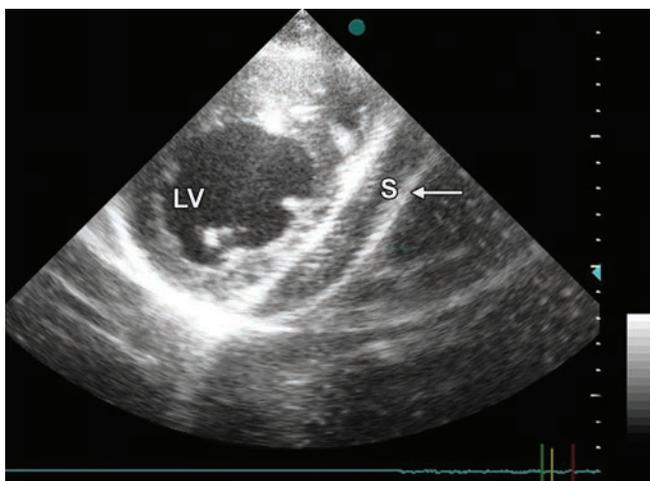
2D echocardiography. Short axis view. Arrow shows space(S), adjacent to left ventricle(LV).
